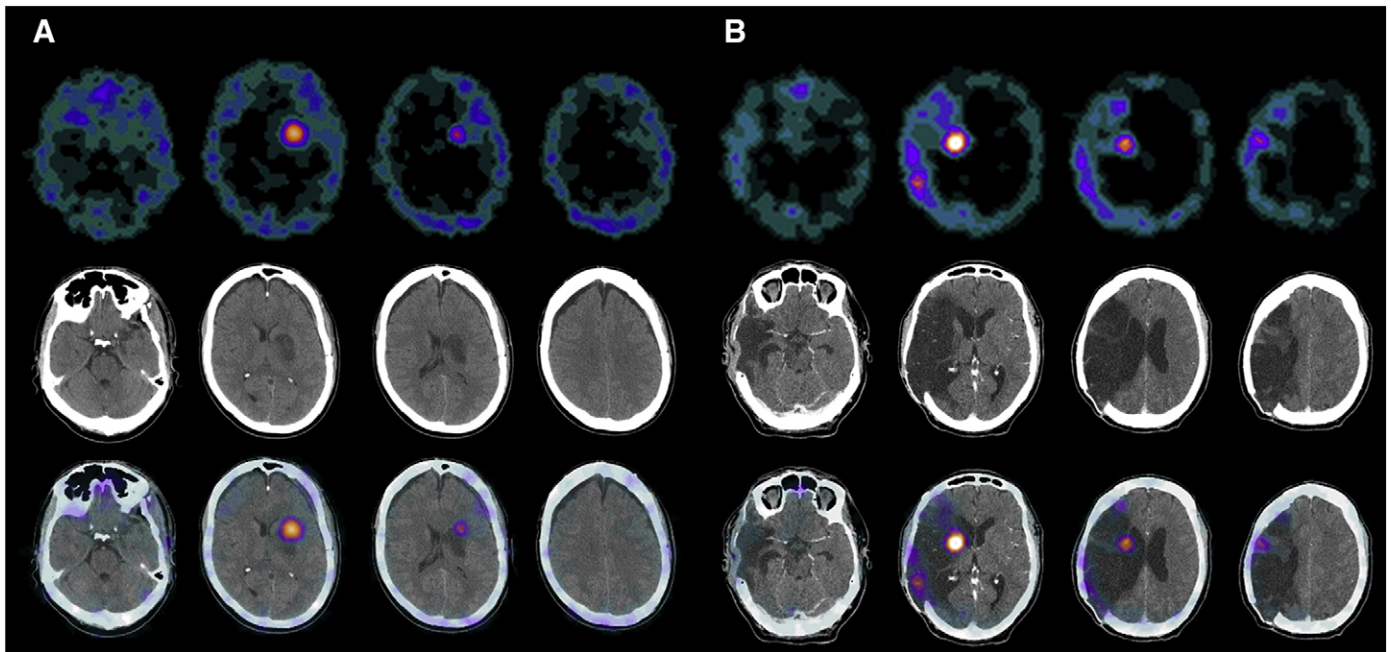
Transverse views of SPECTs (upper row), CTs (middle row) and SPECT/CT fusion images (lower row) of patients 3 (A) and 6 (B).
